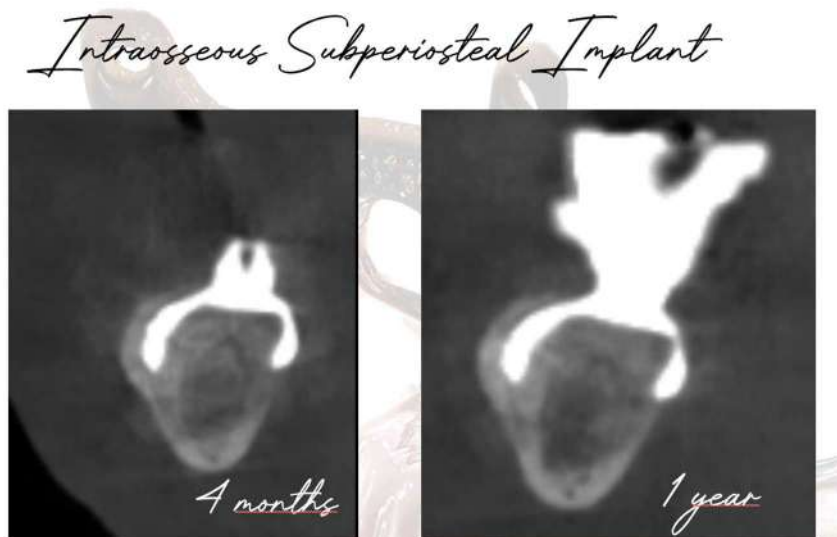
Radiographic comparison (left to right): 4-month and 1 year postoperative. Bone regeneration above the implant arms is clearly visible.
